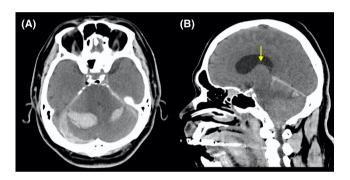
Computed tomography image of the head on admission showing (A) bilateral cerebellar hemorrhage and (B) ascending herniation of the brainstem (yellow arrow).
